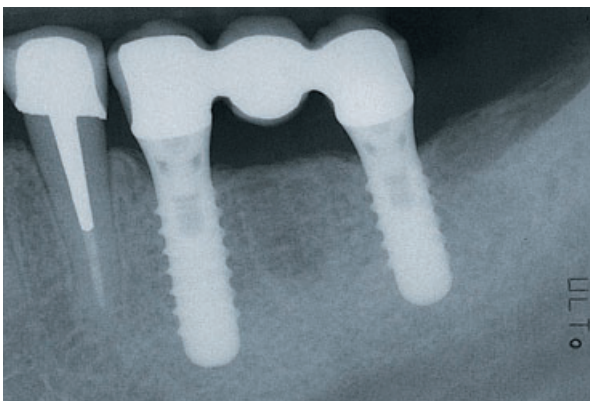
The related 3-year follow-up radiograph documents an only minimal distance between implant shoulder and occlusal surface. Under such conditions, a slight reduction of the alveolar ridge prior to implant placement would have provided more vertical leeway for compensating the lingual implant position and ultimately for covering the occlusal screw.
